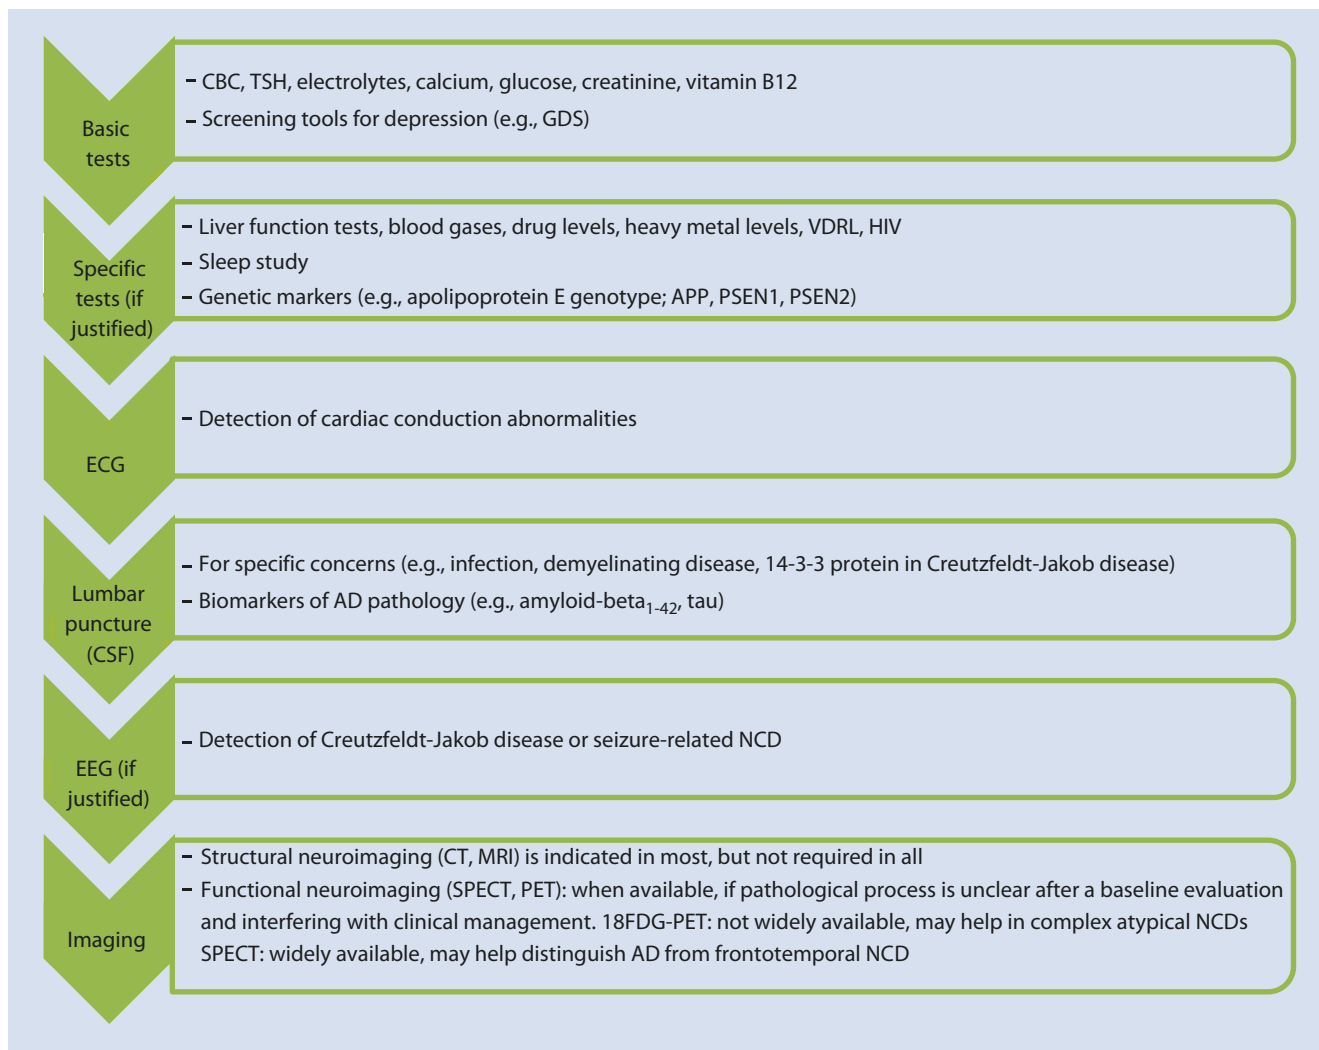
Summary of the diagnostic investigations for Alzheimer disease [36, 44]. Note: AD Alzheimer disease; APP amyloid precursor protein; CSF cerebrospinal fluid; CT computed tomography; HIV human immunodeficiency virus; MRI magnetic resonance imaging; NCD
